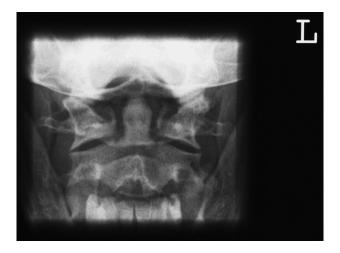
Example of an antero-posterior C1–C2 cervical spine radiograph.
